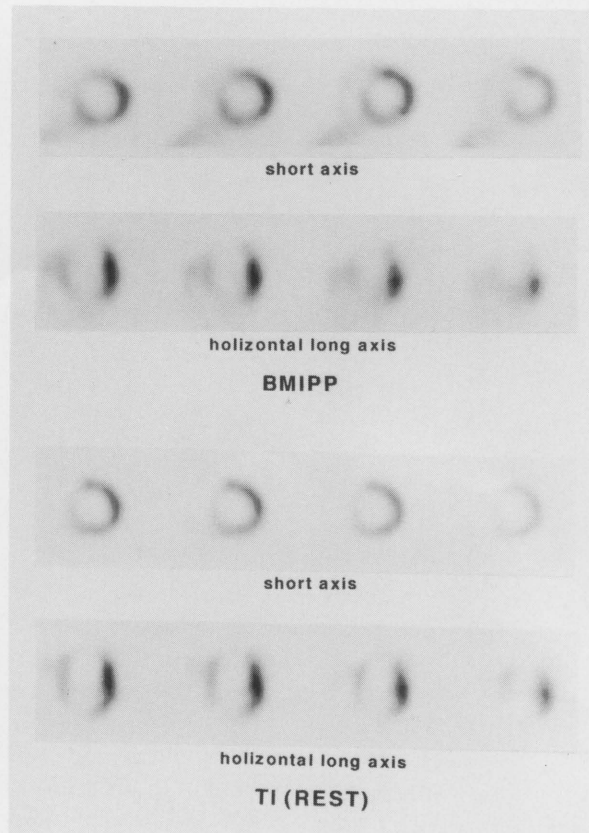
60-year-old man with antero-septal MI after 13 months from onset. Coronary arteriogram revealed 90% stenosis of LAD #6. Left ventriculogram showed dyskinesia of Seg. 2 and Seg. 3 and akinesis of Seg. 6. A series of short-axis and horizontal long-axis slices of BMIPP images (Top) and TI images (Bottom). Both images show concordant distribution. This case showed no significant FDG uptake in the PET study.
